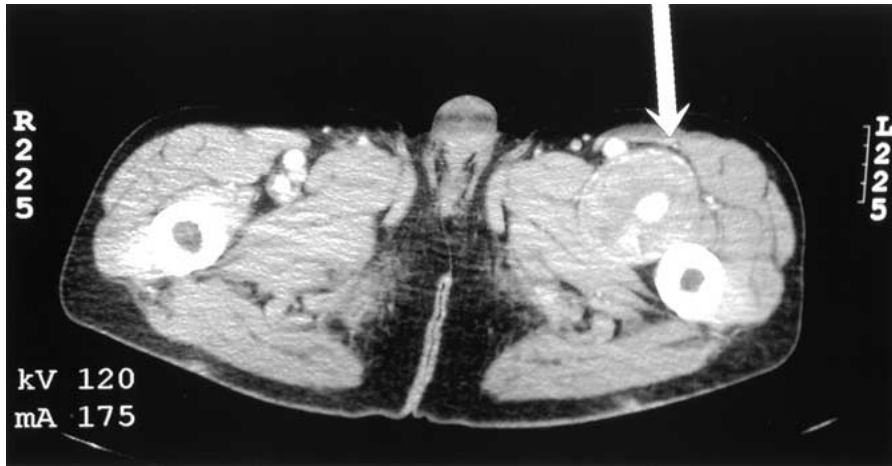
Computed tomography of proximal thigh: arrow indicates 6-cm aneurysm of the PFA.
